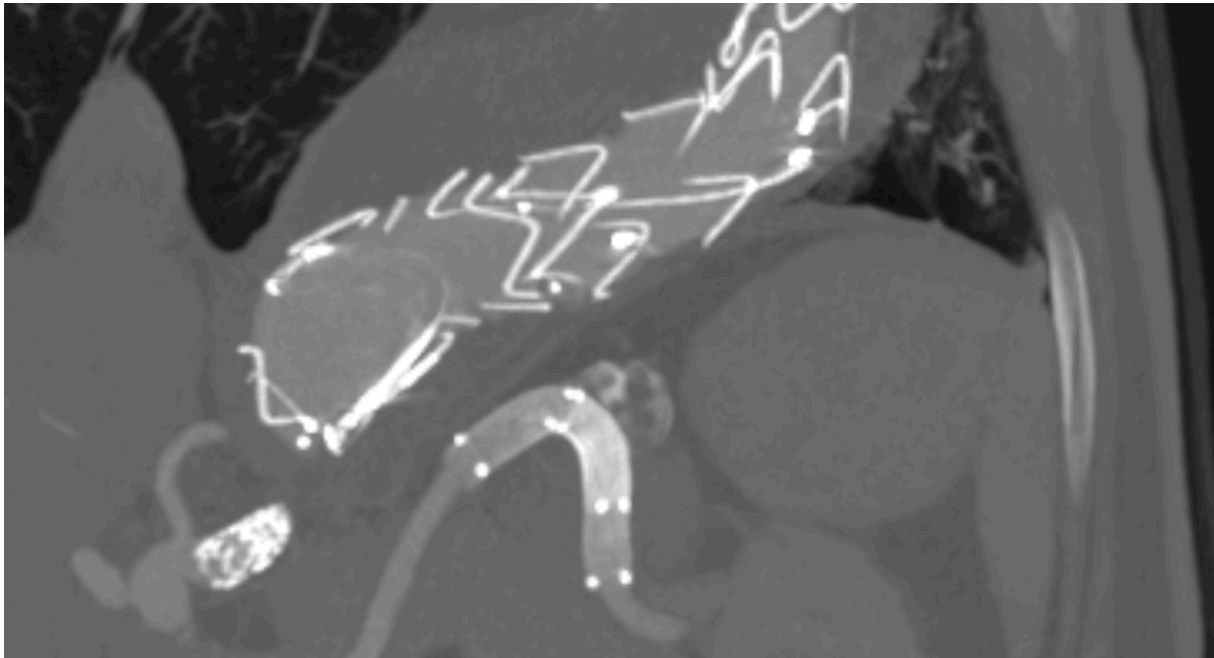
1-year follow-up in contrast-enhanced CT with partial visualization of the EVAR, stented left renal artery with primary fenestration of the EVAR, and stenting of both renal arteries and the celiac trunk due to the aortic dissection extending into the abdominal aorta and the thrombosed splenic artery aneurysm after Viabahn stenting. Proper perfusion of the visualized sections of the splenic artery
